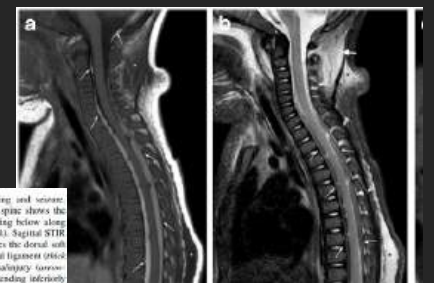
From 10-month-old girl presenting with vomiting and seizures. Sagittal T1-weighted MR image (a) of the upper spine shows the hyperintense subdural hemorrhage (arrows) extending inferiorly along the spinal canal and neural foramina (arrowhead). Sagittal STIR MR image (b) of the upper spine better demonstrates the dorsal sulcus (arrowhead) and ligamentous edema in the thoracic ligament (white arrow), as well as intervertebral ligamentous edema (arrowheads). Note the STIR hyperintense spinal SDH extending inferiorly.
